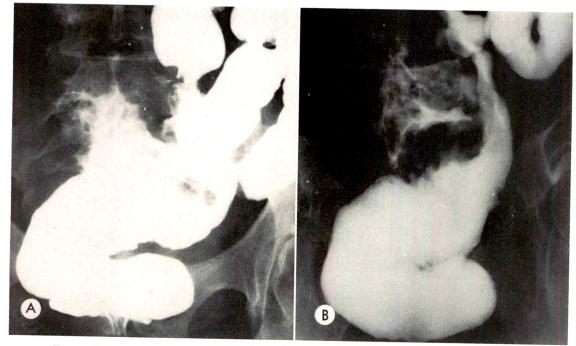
Roentgenograms of a patient with large perforating carcinoma of the rectosigmoid colon. (\mathcal{A}) Anteroposterior view. (\mathcal{B}) Angled view.
